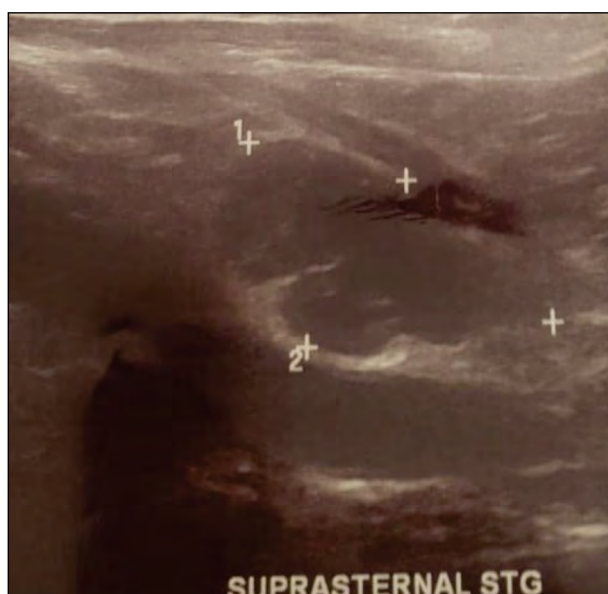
Cervical ultrasound identifies a parathyroid adenoma causing tertiary hyperparathyroidism
